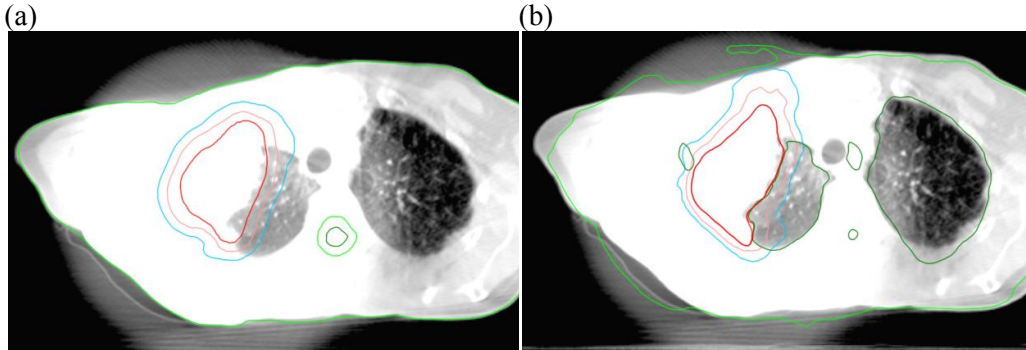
(a) The reference CBCT (fx 15) of patient 2 with manually delineated CBCT structures. (b) The same CBCT (fx 15) overlaid with the dCT structures, i.e. the propagated deformed pCT structures. The red, pink, blue and the outer light green delineations represent GTV, CTV, PTV and body contour, respectively. Colors are available in the online version.
